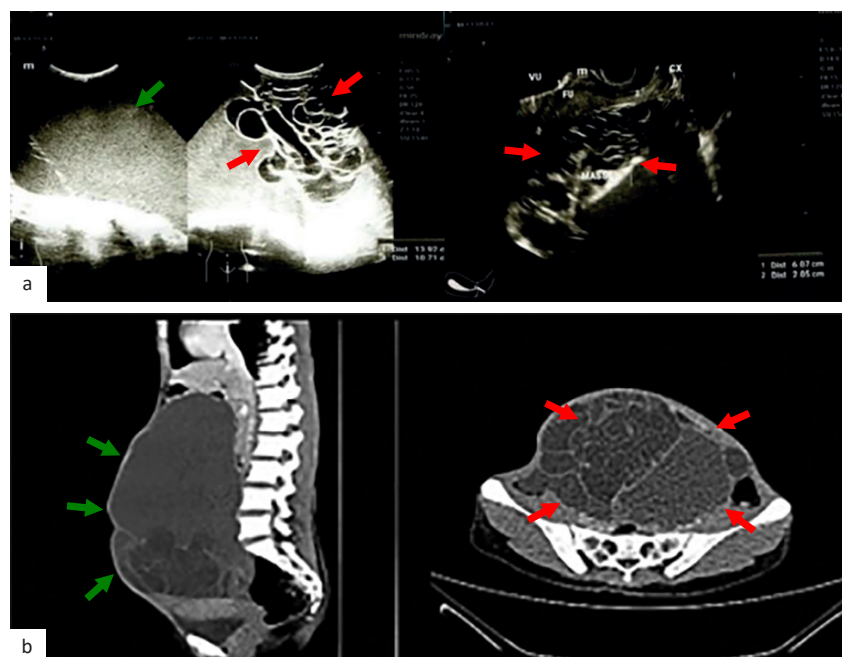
US and CT scan imaging. (a) US image shows a large mass in the right ovary, suspected malignancy of a mucinous type (green arrow) with >10 locules (red arrows); (b) CT of the whole abdomen image shows a large (green arrows), septated cystic mass (red arrows) in the right ovary, measuring 12.8 × 22.1 × 25.8 cm, without signs of infiltration into surrounding organs. CT=computed tomography; US=ultrasound
